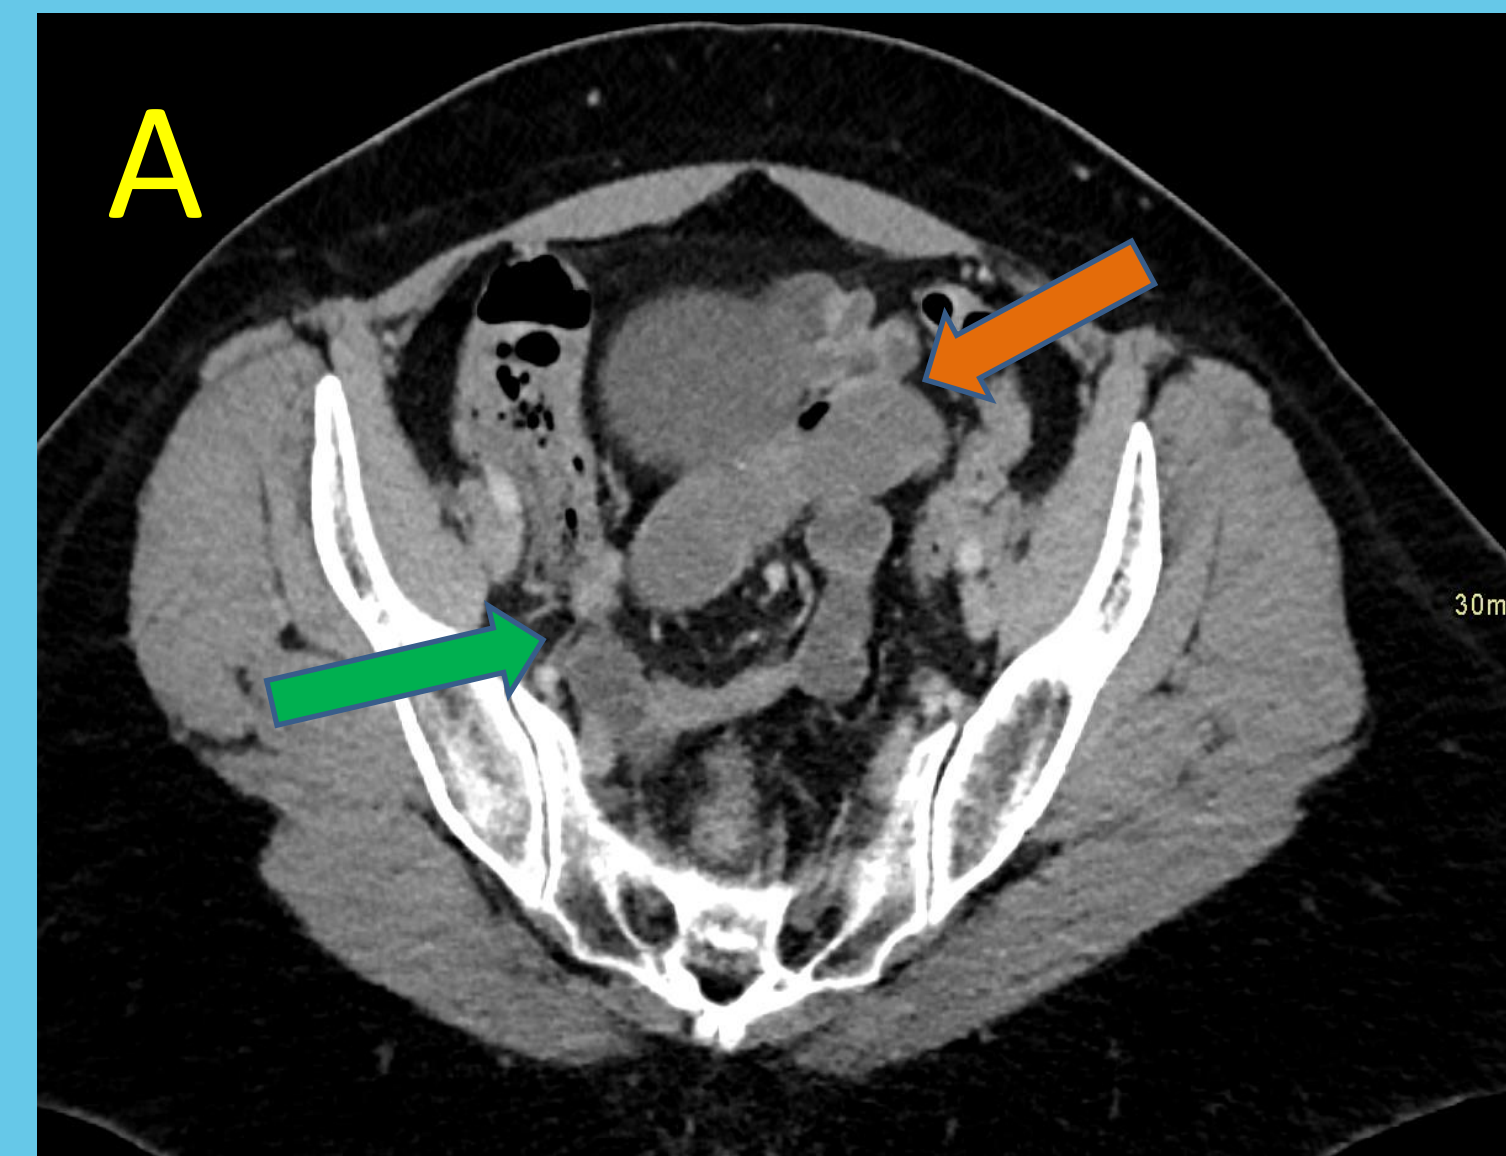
CT Abdomen and pelvis with IV Contrast with a green arrow in A pointing to the collapsed ileum, and an orange arrow pointing to partially dilated upstream small bowel
